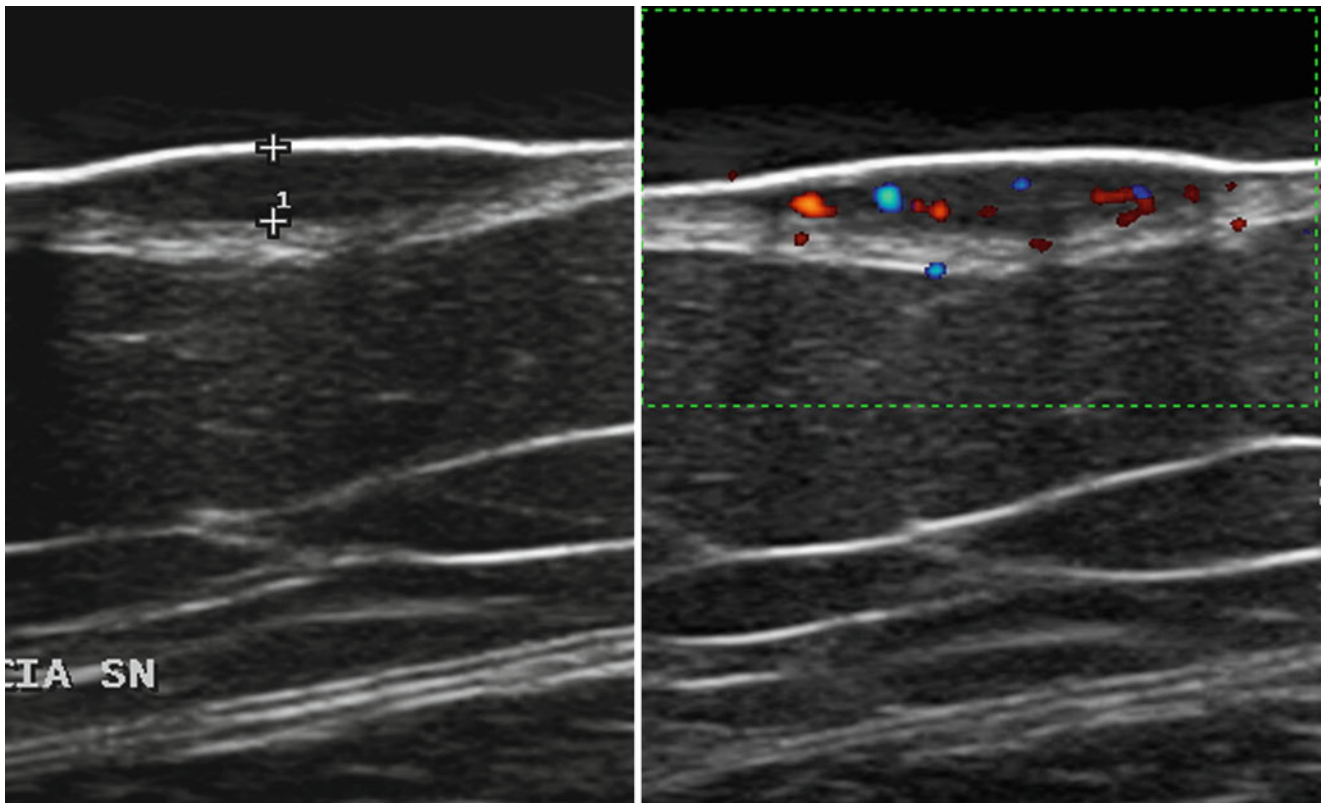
Primary melanoma of the thigh. Image taken with a gel pad spacer. The 1.9-mm thick melanoma shows multiple internal flow signals in the power Doppler side of the split mode image
